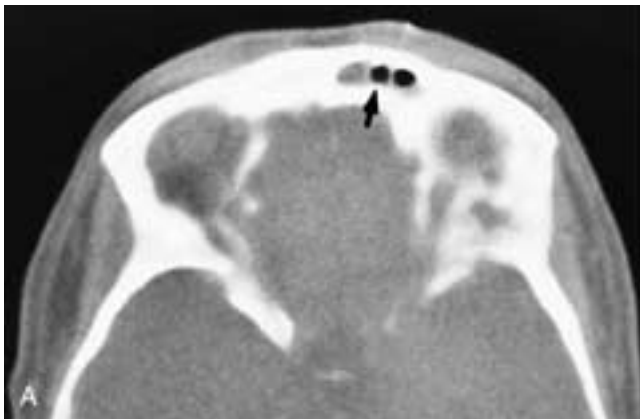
Axial CT scan (A) shows an air-filled tube (arrow) in the left frontal sinus. The sinus is partially filled with secretions. Axial CT scan (B) through the ethmoid sinuses shows the drainage tube (arrow) extending down into the nose. There has been an external ethmoidectomy, and the anterior lamina papyracea has been removed. The left ethmoid cavity and the left sphenoid sinus have inflammatory changes.
